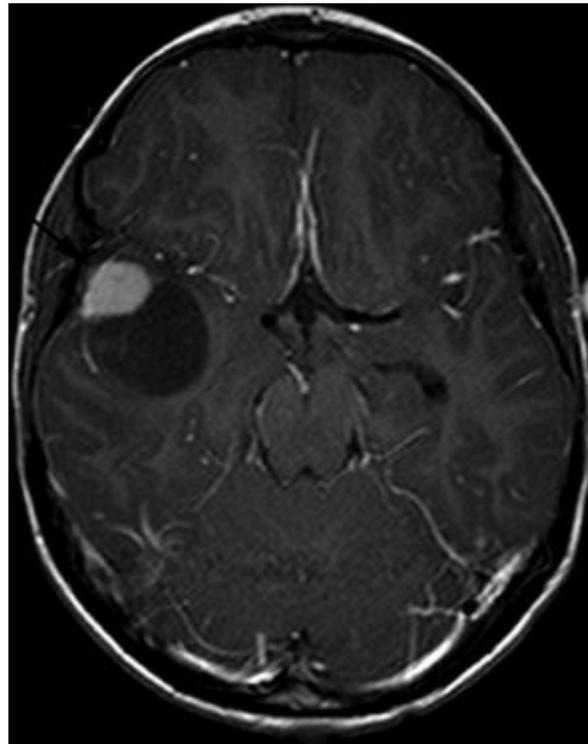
Pleomorphic xanthoastrocytoma. Axial T1-weighted image from MRI with gadolinium in a 10-year-old boy with a 1-year history of headache shows a lesion involving the cortex and subcortical white matter of the right temporal pole characterized by a large cyst with an enhancing mural nodule (arrow) without significant surrounding edema.
